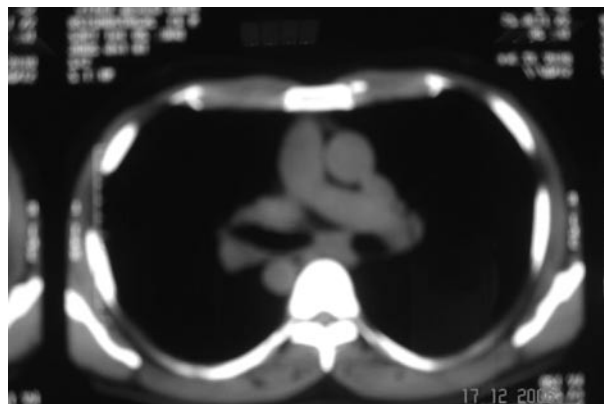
Thoracic CT scan showing mediastinal lymph nodes
